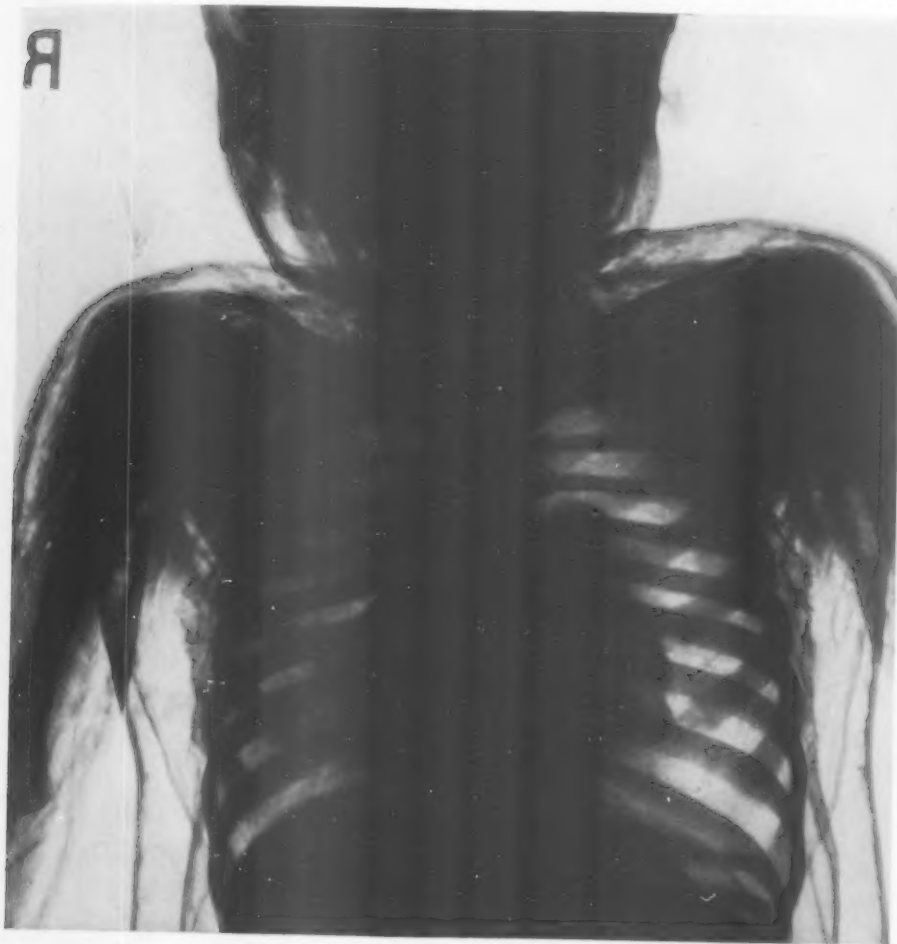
Radiograph of upper part of body same patient. Note pneumothorax.
